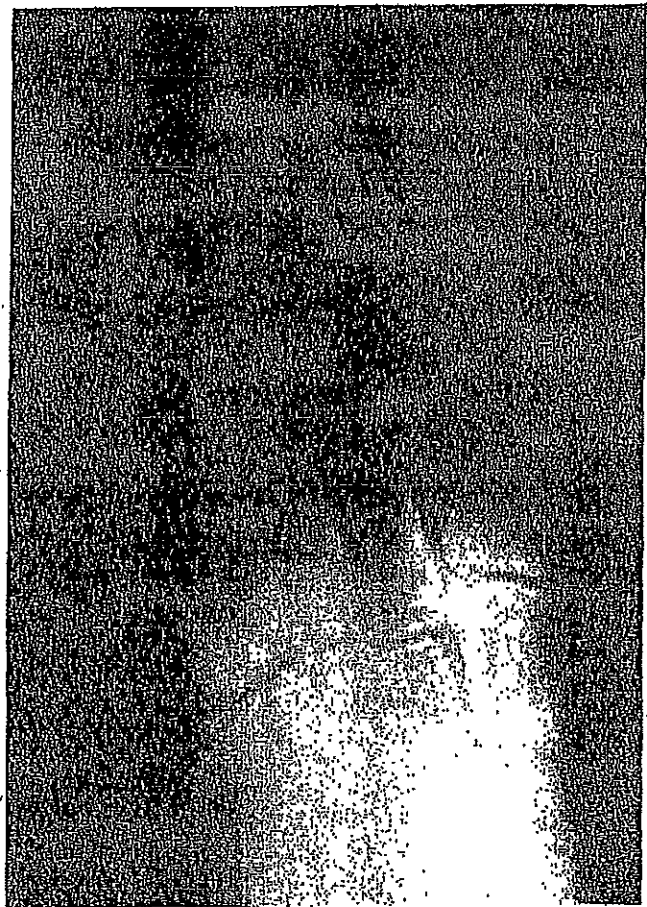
Anteroposterior weightbearing radiograph of the left foot 30 months postoperatively. An osteolytic lesion (arrows) remains at the site of the poly-lactic acid screw tract across the first tarsometatarsal joint.
